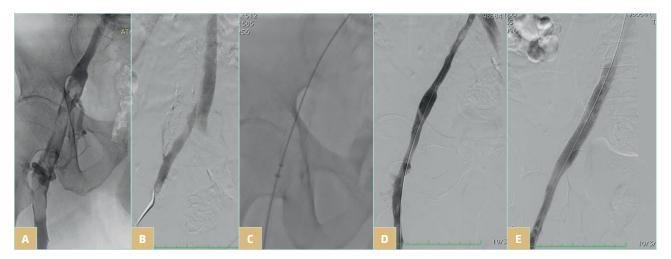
Symptomatic iliofemoral deep venous thrombosis (DVT) managed with ClotTriever (Inari Medical) mechanical thrombectomy and placement of a 14x 100 m BeYond (Bentley) stent: A) thrombus at the iliofemoral segment extending distally to the origins of the femoral and deep femoral veins; B) clean but diseased proximal iliac segment (notice the presence of collateral vein); C) mechanical thrombectomy (notice the coring element and the collection bag of the ClotTriever device); D) venogram post thrombectomy with almost complete thrombus resolution but residual stenosis (confirmed also with intravascular ultrasound); and E) final venogram after stent placement indicating brisk flow through the previously thrombosed iliofemoral segment.
